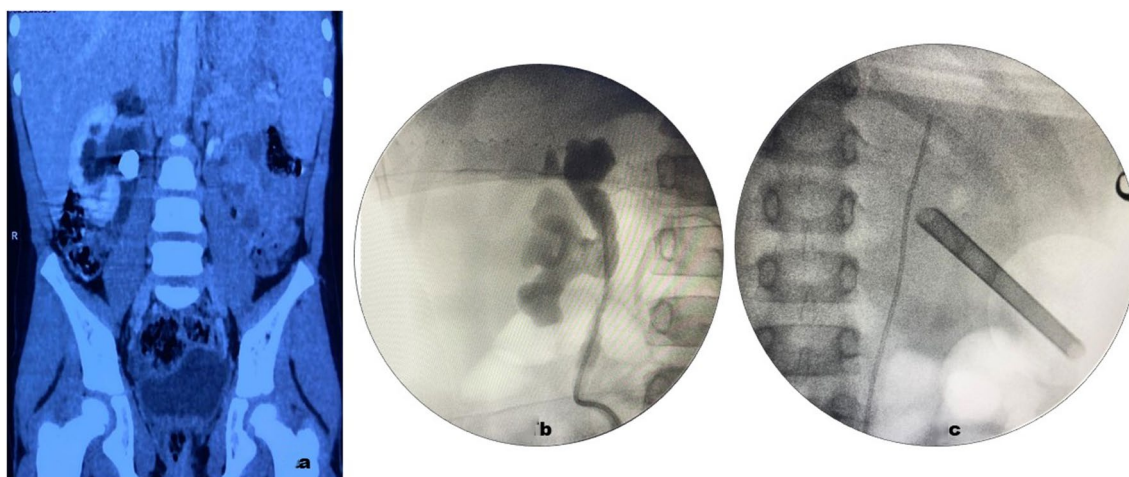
a CT scan shows a 14 mm Rt. renal calculus in a 9 yrs. old boy. b A pre-PCNL Rt. retrograde pyelography. c Shows complete clearance of stone following PCNL
